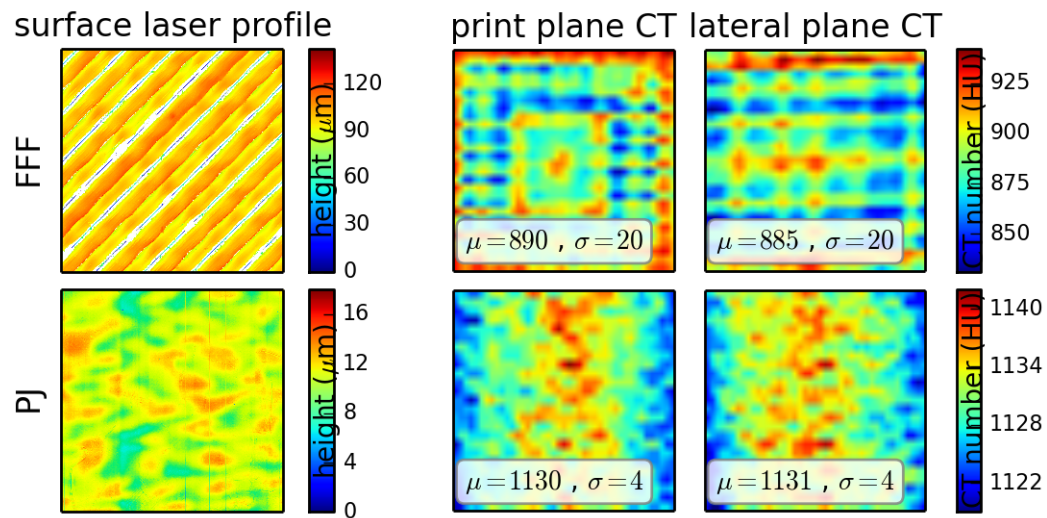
$5\text{mm} \times 5\text{mm}$ laser profilometer surface scans (left) for the FFF (upper) and PJ (lower) test cubes – white is unreadable, color scale is relative to lowest measured point. CT slice (0.4mm thickness) images perpendicular to the print direction (middle), and lateral direction (right) – μ is the mean; σ is the standard deviation.
